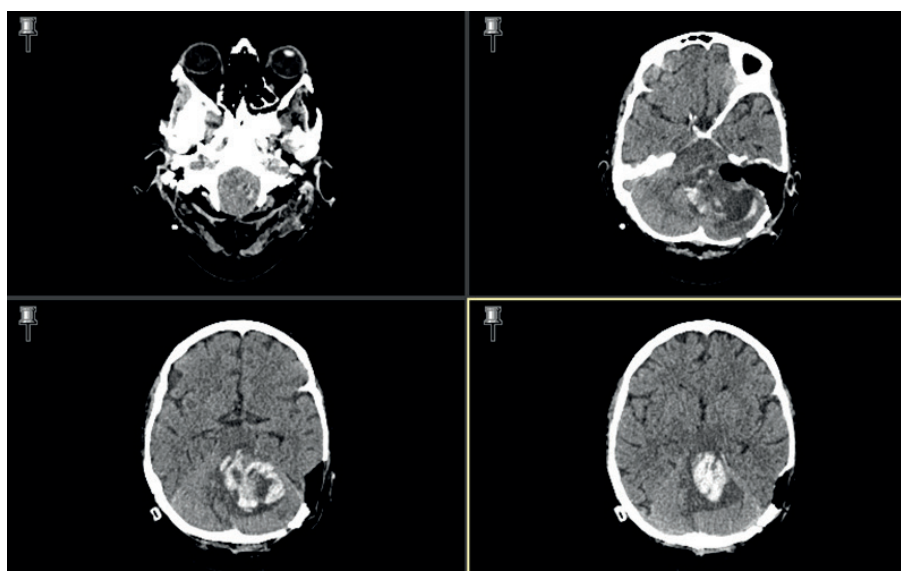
CT head showing acute hemorrhage within the tumor bed with mass effect.
